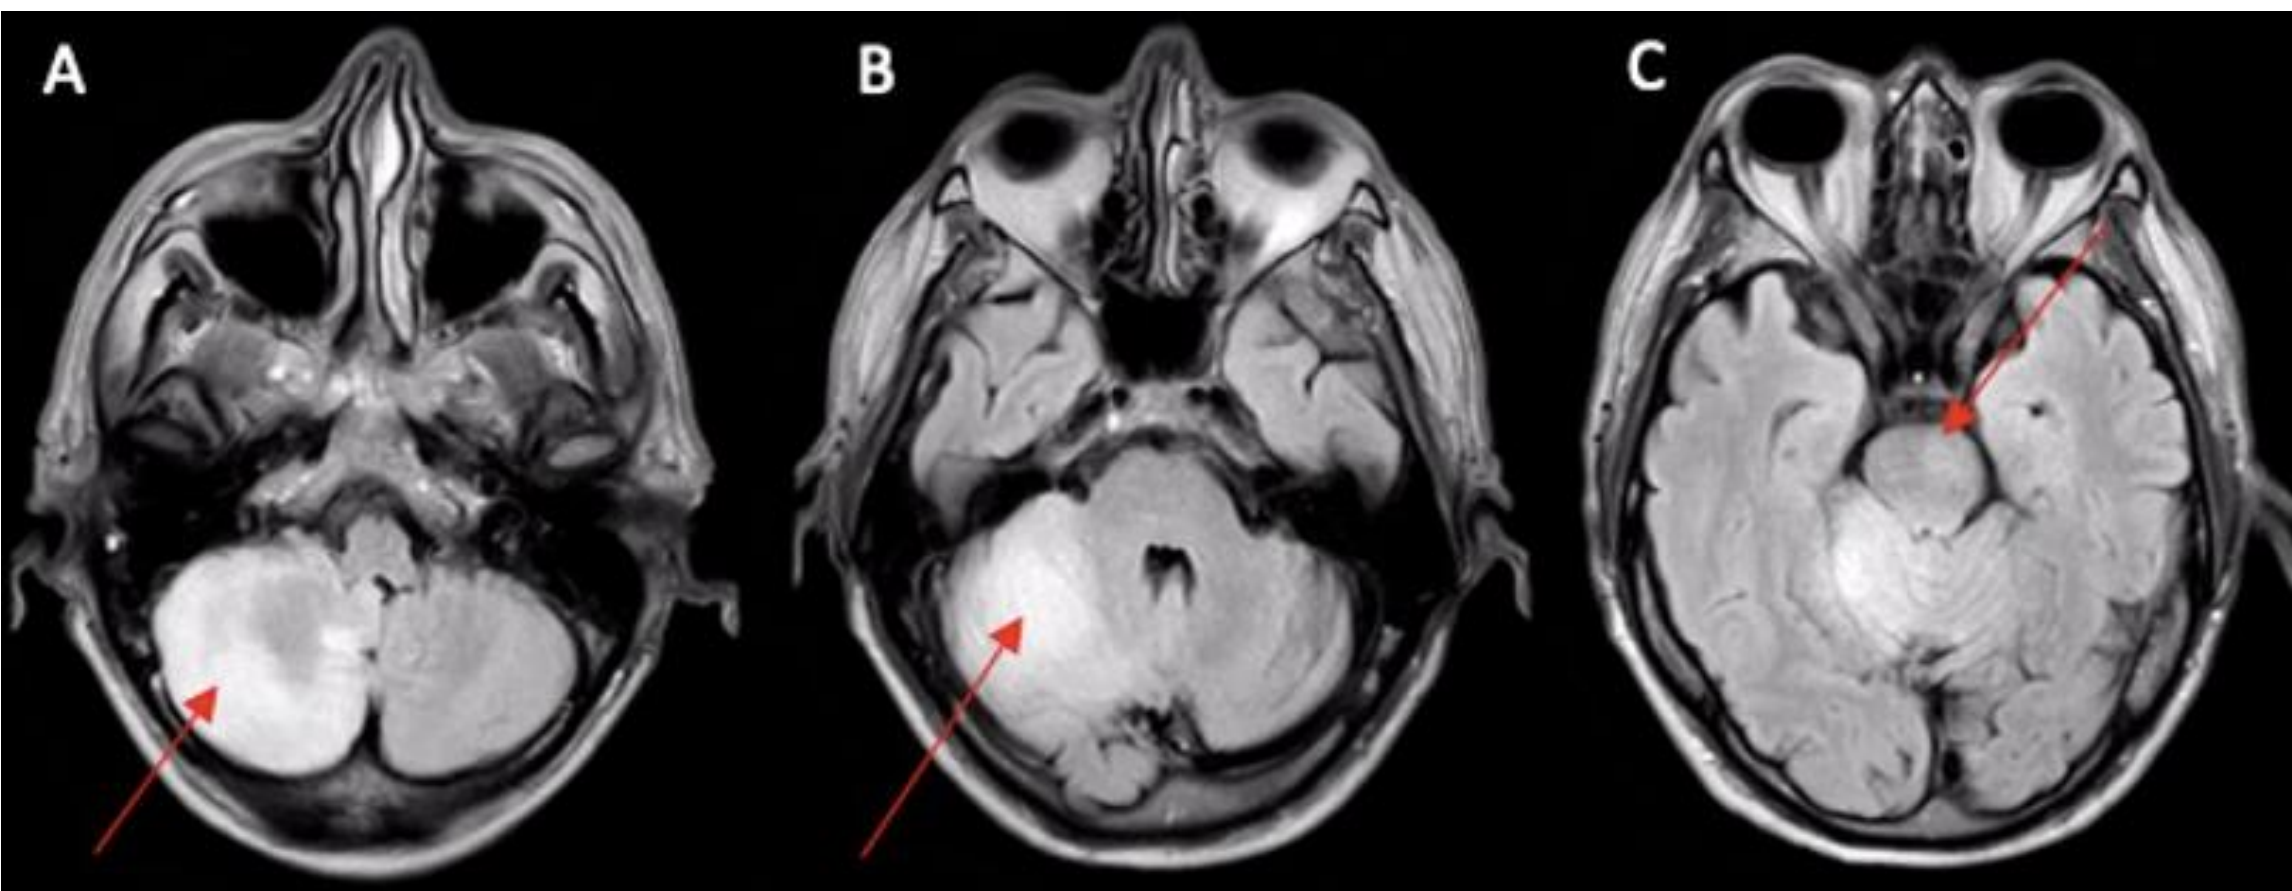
Axial T2-weighted MRI demonstrating multifocal posterior circulation infarcts. (A) Right cerebellar hyperintensity at the level of the inferior cerebellar peduncles; (B) right cerebellar hyperintensity at the middle cerebellar peduncle; (C) left paramedian pontine hyperintensity at the rostral pons. Red arrows indicate areas of abnormal T2 signal consistent with embolic vertebrobasilar ischemia.
